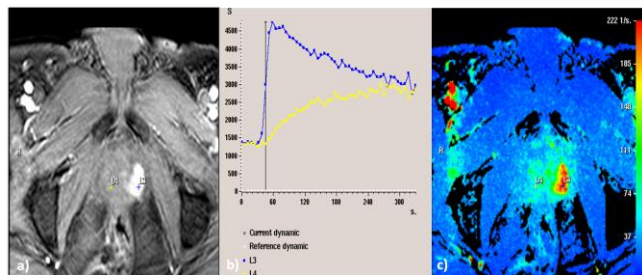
DCE-MRI of PCa in the left peripheral zone corresponding to the same tumour in Figure 6 + Figure 9. The a) dynamic contrast enhanced T1W image and the c) corresponding DCE colour map show early focal contrast enhancement in the tumour (red area). b) The dynamic DCE-curve L3 (blue) is a typical malignant curve (curve type 3) with a high peak, rapid early enhancement (high wash-in rate) and early wash-out. The DCE-curve L4 (yellow) is from a non-malignant region with no early wash-out (curve type 1). (Source [52]. Reprinted with permission from the publisher).
